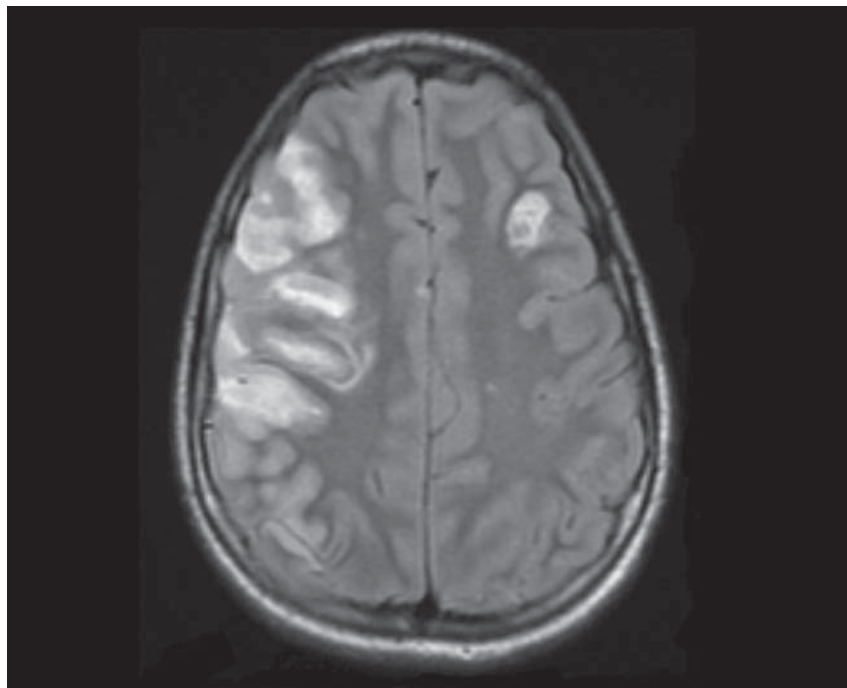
Magnetic resonance image of the head of the patient, a 13-year-old boy, showing multiple areas of infarction bilaterally with the largest in the right middle cerebral artery distribution and a smaller one in the left frontal region consistent with embolic infarcts.
